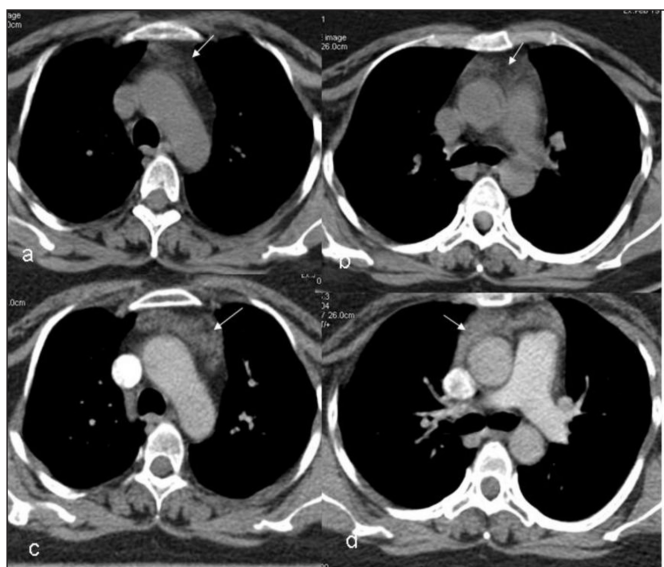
Axial CT of 30-year-old male patient before chemotherapy, no thymic remnant seen in widened fat-filled mediastinum (a,b). 3 months after chemotherapy CT shows anterior mediastinal fat attenuation lesion and the typical thymic appearance
